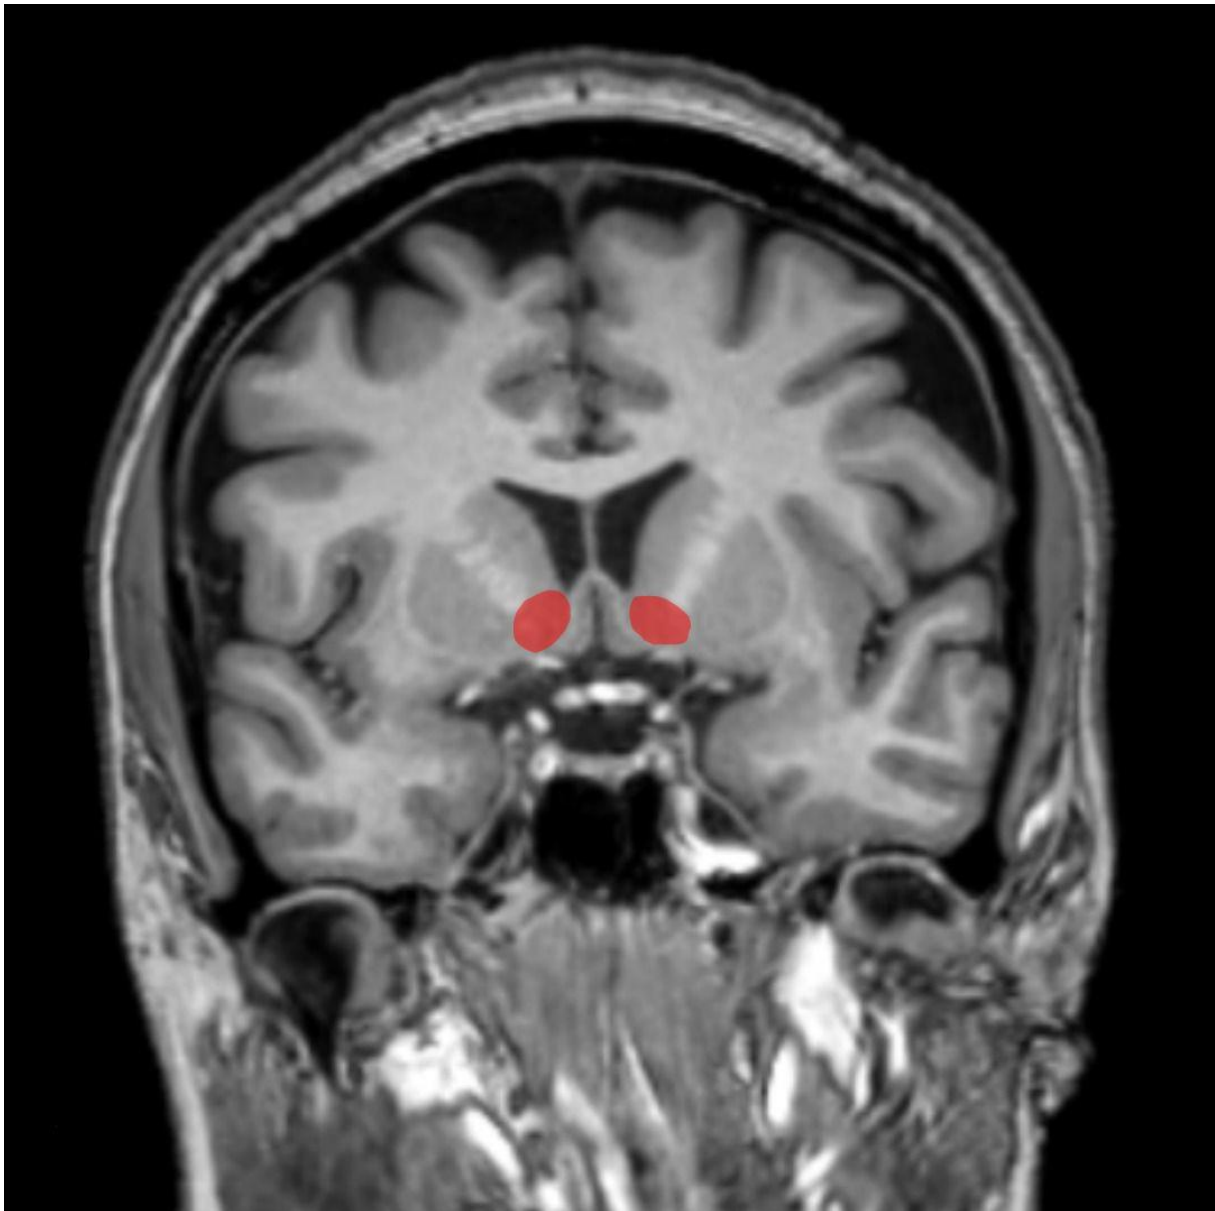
T1-weighted MRI frontal slice showing the Nucleus Accumbens (NAc) and its limits with the caudate nucleus and putamen.
